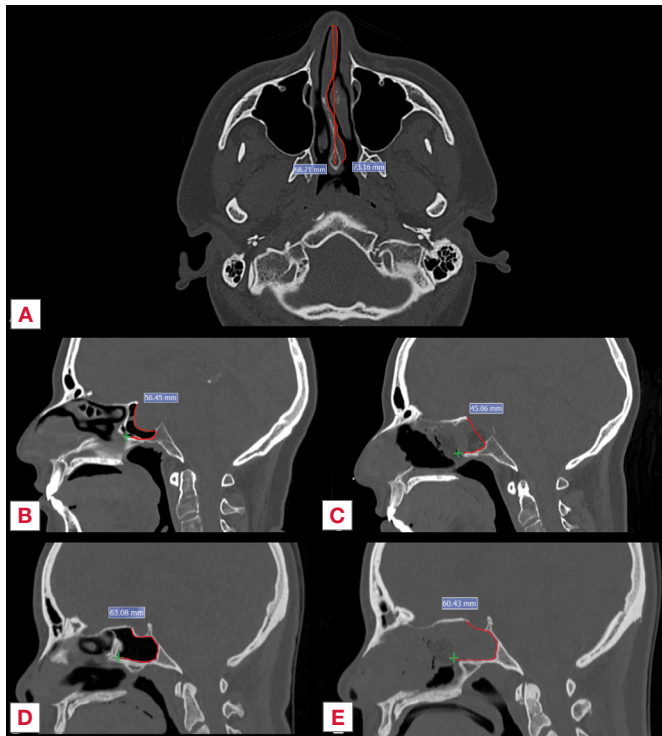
A) Nasal septal deviation in the anteroposterior direction. In red, comparison of two methods for measurement of the nasal septum, one in a straight line and the other following its curves; B and D) Preoperative image showing CT-Est, i.e., the estimated minimum size of the nasoseptal flap to cover the defect created by a sellar approach; C and E) Postoperative image showing the possible position of the flap. Removal of the sellar bone shortens the distance required for the flap to reach the tuberculum sellae.
